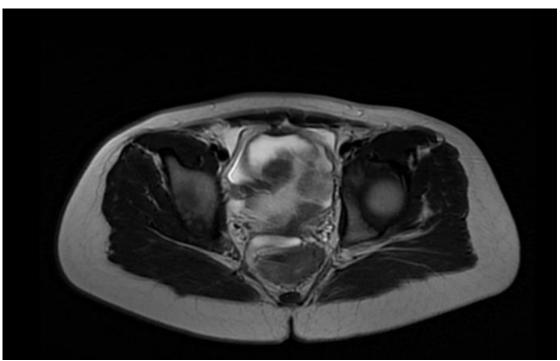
Uterine hypoplasia with partial vaginal agenesis on pelvic MRI in axial section
